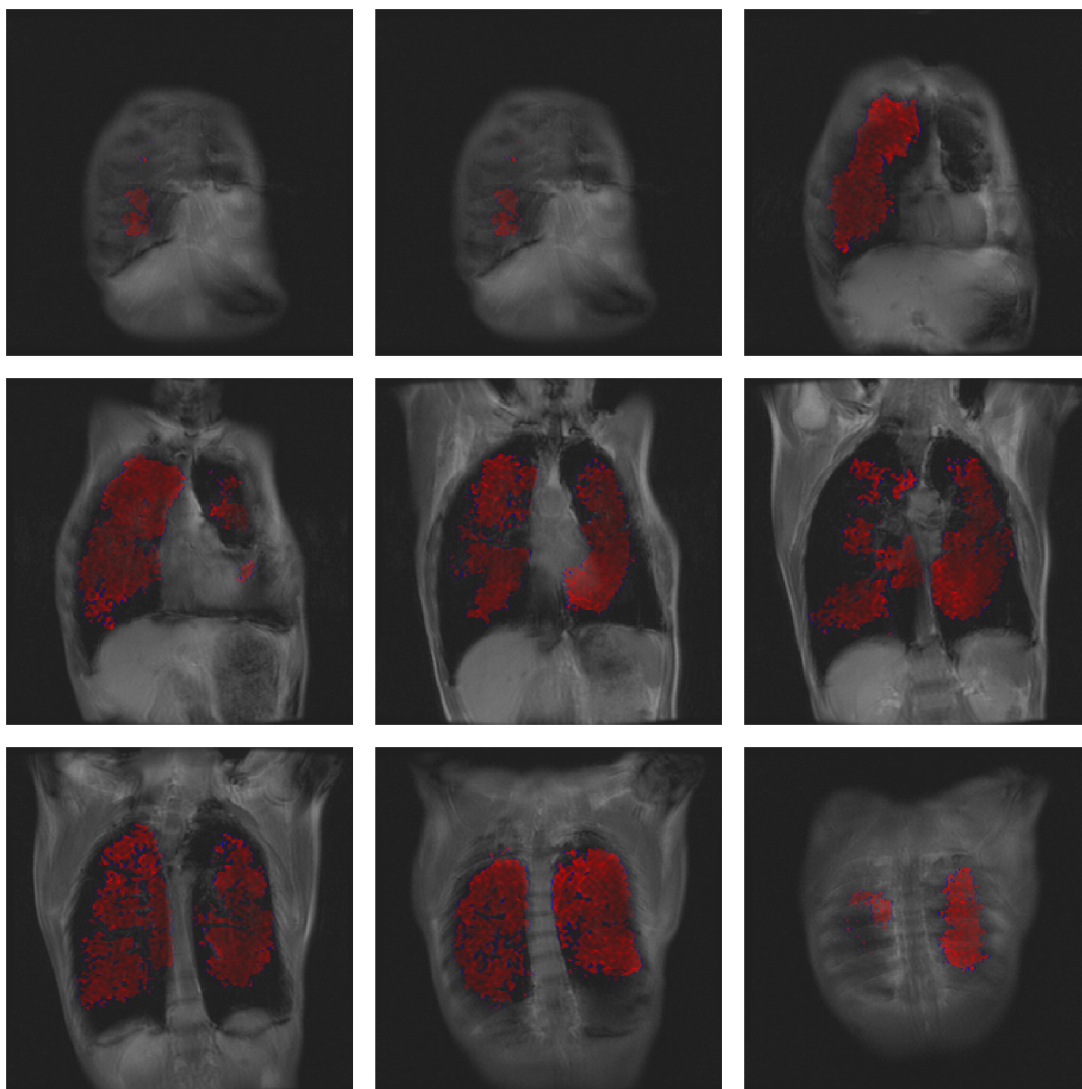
Coronal HP ^{129}Xe -MR diffusion-weighted imaging co-registered to proton MRI acquired from OXF0139.
